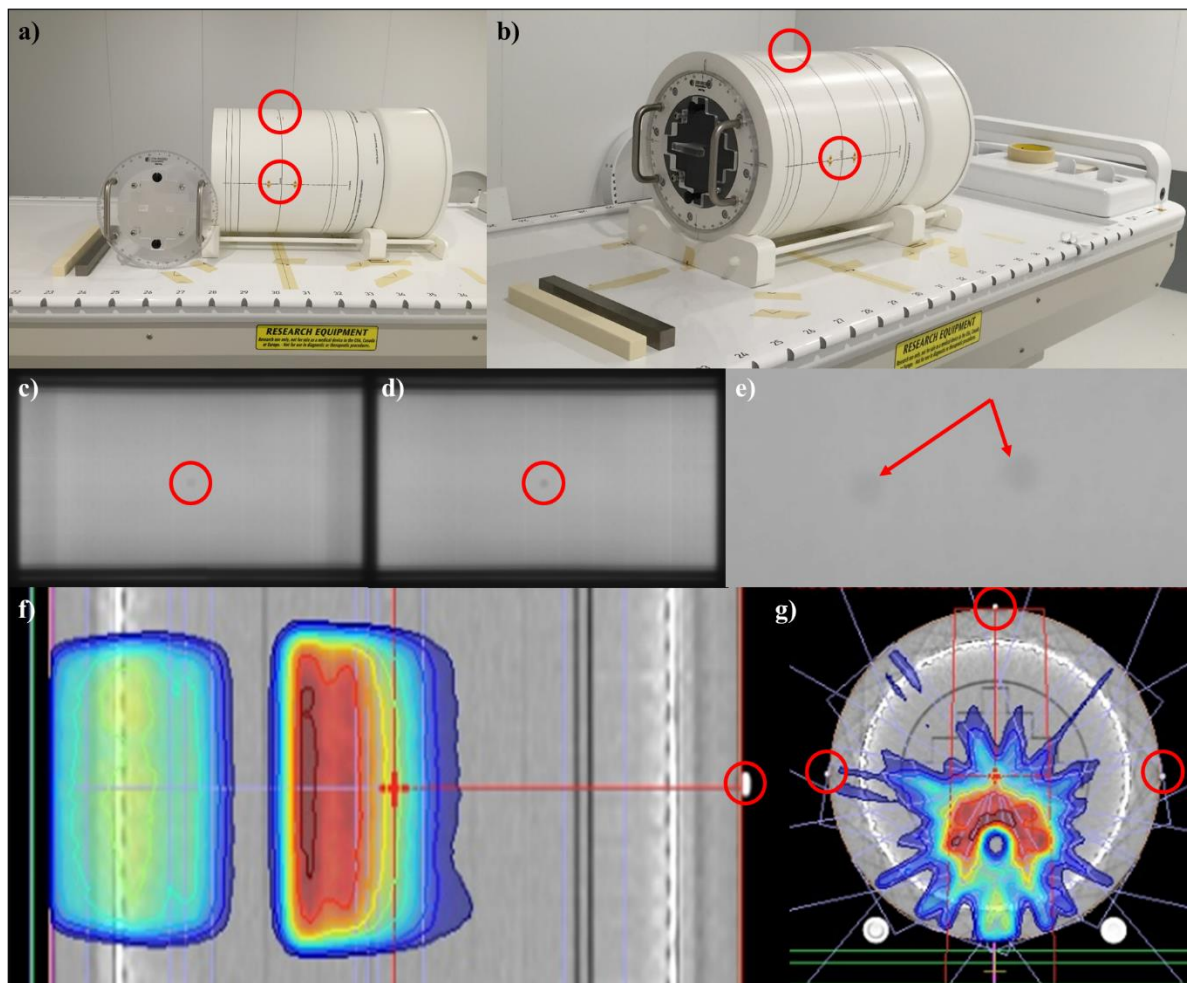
a) and b) Images of ArcCHECK-MR showing locations of radio-opaque ceramic BB markers, c) view of BB on EPID with gantry angle at 0° (BB should be in center of field of view if positioned correctly, side BBs not visible in this acquisition due to size of EPID field of view), d) view of BB on EPID with gantry angle at 90° or 270° (BBs should be centered and overlap if positioned correctly), e) example of mis-aligned ArcCHECK-MR with BBs not overlapping, f) CT of BB used for initial isocenter positioning in Monaco TPS, and g) CT of BBs on ArcCHECK-MR used for initial isocenter positioning in Monaco TPS.
